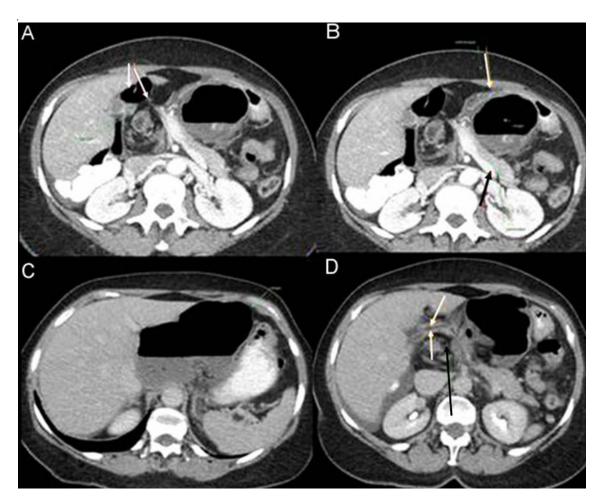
Contrast-enhanced computed tomography. Axial plane. A. Mesenteric fat passing through the hiatus of Winslow surrounding the colonic walls (arrows). B. Cecal contents in the internal hernia, displacement of the stomach forward (white arrow) and the pancreas backward (black arrow).
